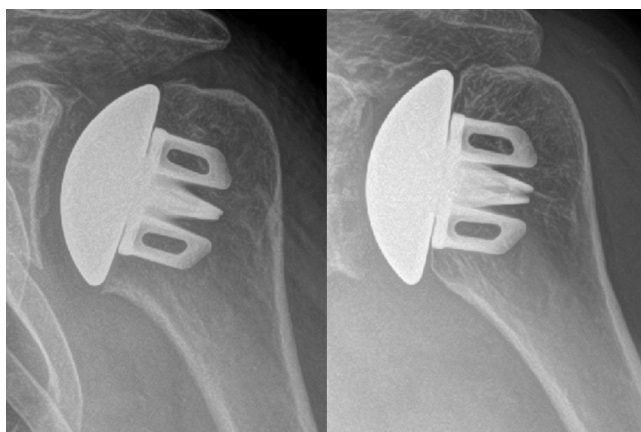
Immediate postoperative (left) and 1 year postoperative (right) anteroposterior radiographs. The right image shows zone 3 partial cortical thickness resorption, i.e. medial calcar osteolysis or stress shielding, as well as zone 1 partial cortical thickness resorption.
